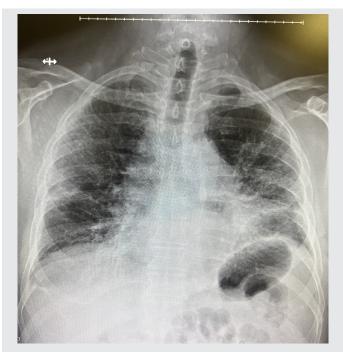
Chest x-ray 1 month prior to this admission.
